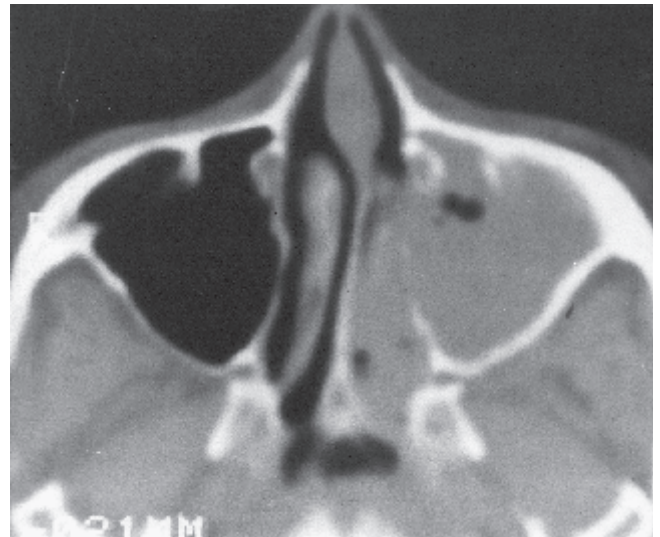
Axial CT-scans from a 39-year-old female patient before (a) and 6 months after FESS (b) performed for an ACP. After surgery the sinus mucosa remains severely thickened, while the window in the middle meatus is wide and patent.
